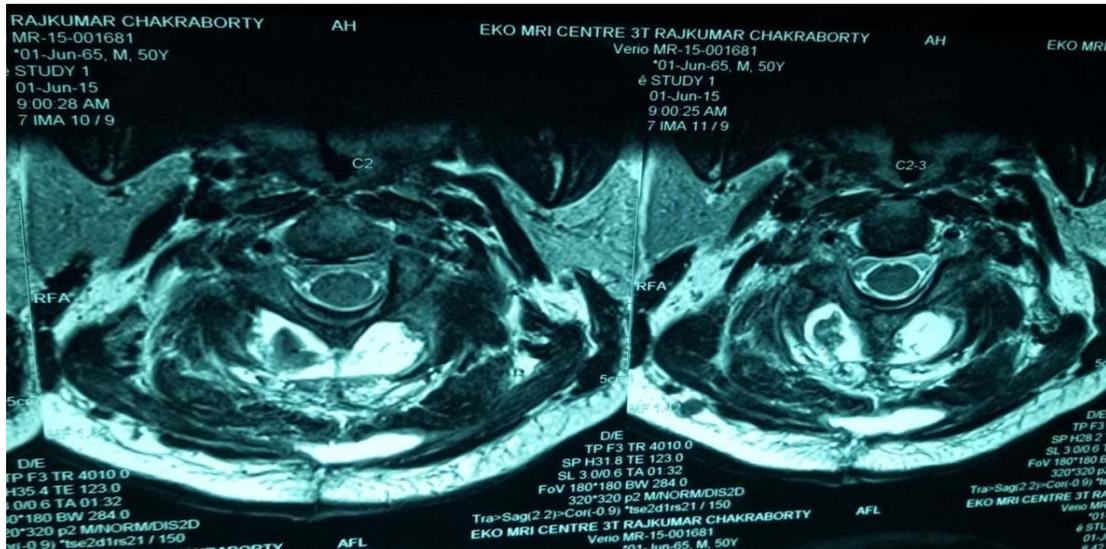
Post-op T2 MRI, axial & coronal section
